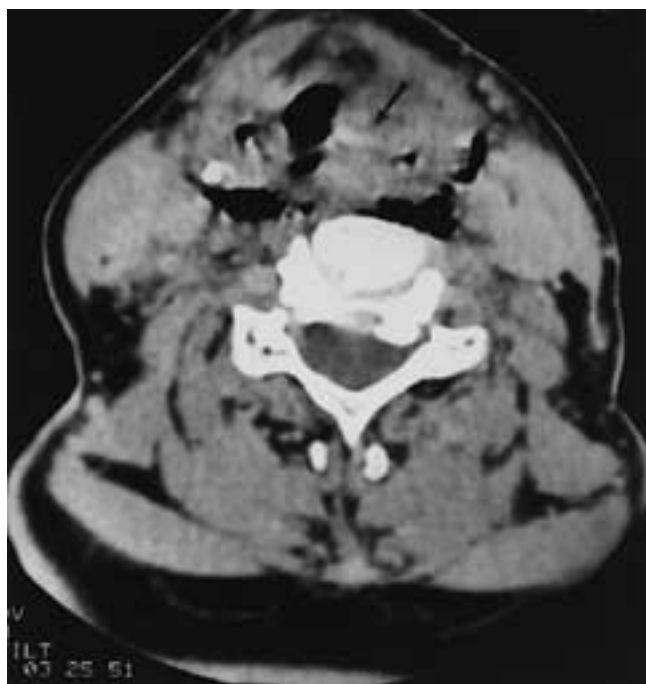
Vehicular injury. Axial CT of a hematoma of the larynx and laceration of the pharynx. There is a hematoma (*arrow*) of the AE fold. The gas in the soft tissues is from laceration of the pharyngeal wall.
